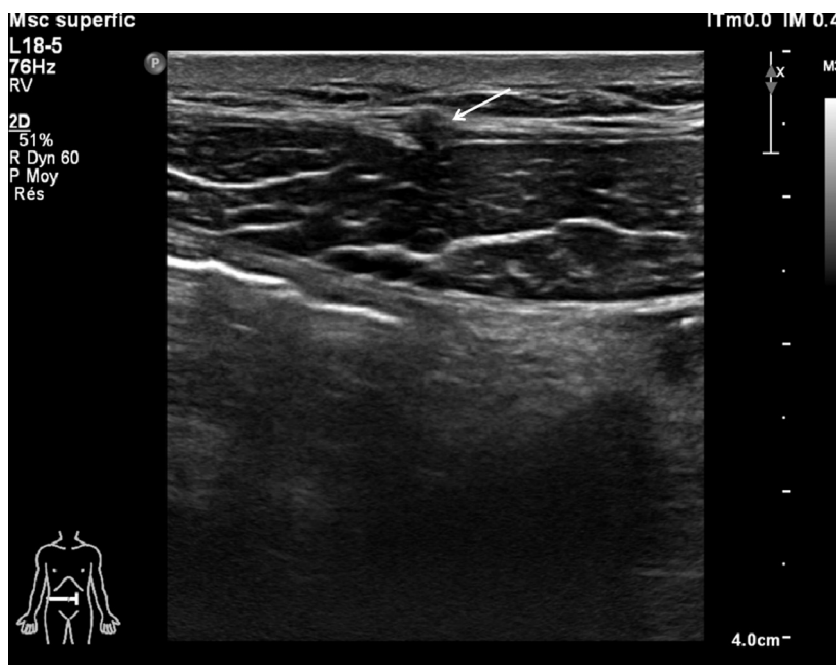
Doppler US showing thrombophlebitis of the inferior epigastric veins superficial to the rectus abdominis muscle on the right.
